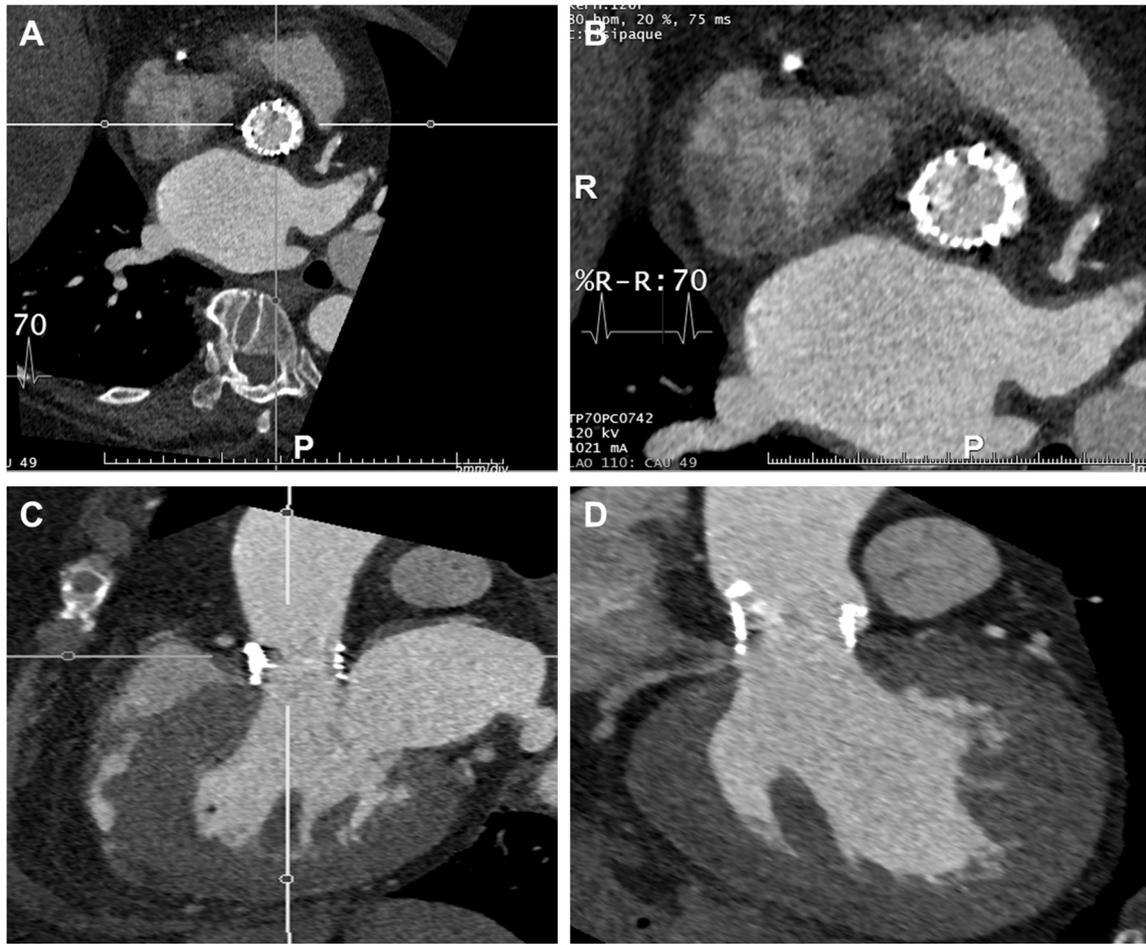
Use of Pre-operative CTA with retrospectively gated image acquisition of the heart revealed heavily calcified leaflets of the aortic valve.
